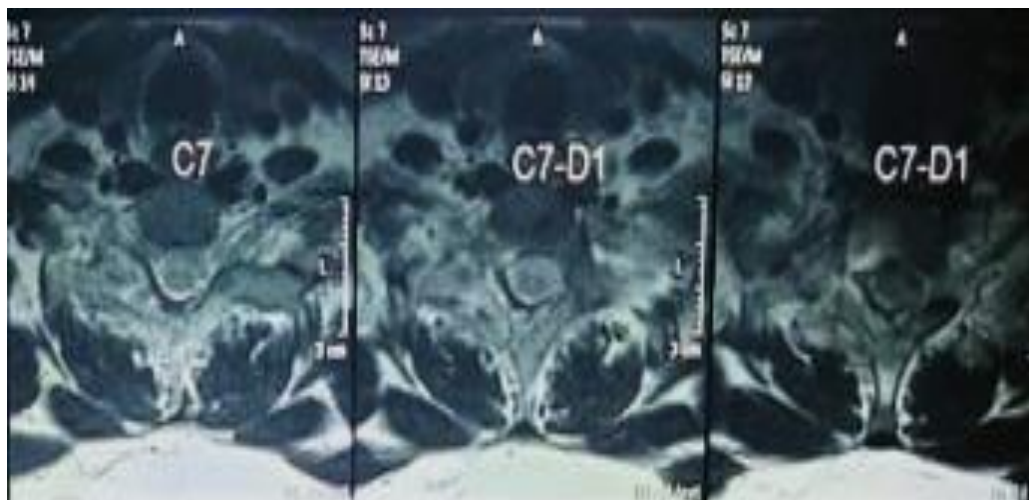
MRI cervical spine axial sections which show altered signal intensity in the anterior epidural space and the paraspinal soft tissues.
